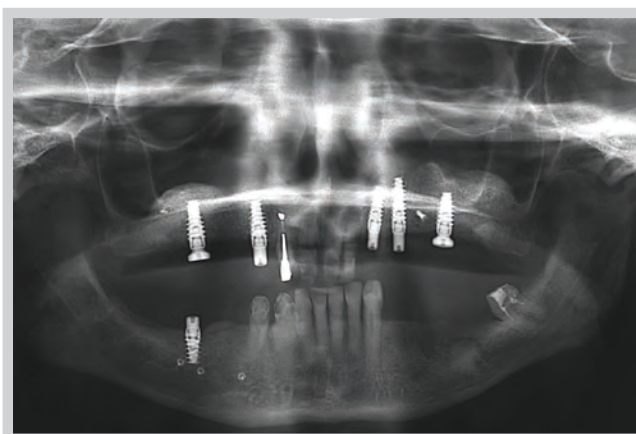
A radiograph showing placement of five implants in the upper jaw to replace the back teeth and one implant in the lower jaw to assist retaining a lower partial denture.
